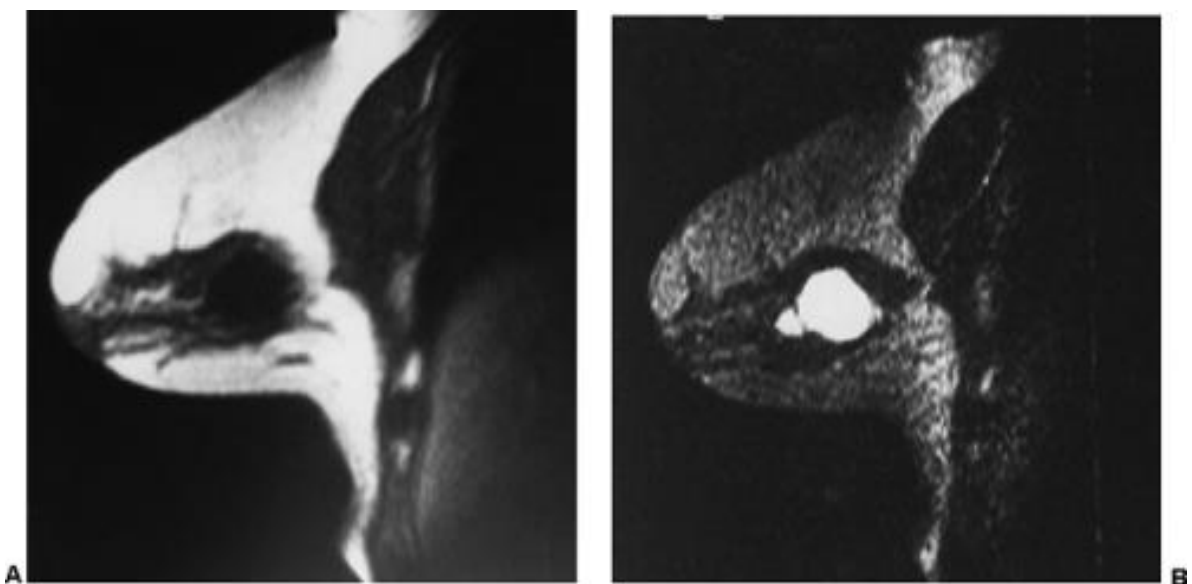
It is shown a cyst that has a characteristically low signal intensity (black) on the T1-weighted image (A) and a high signal intensity (white) on the T2-weighted image (B).
